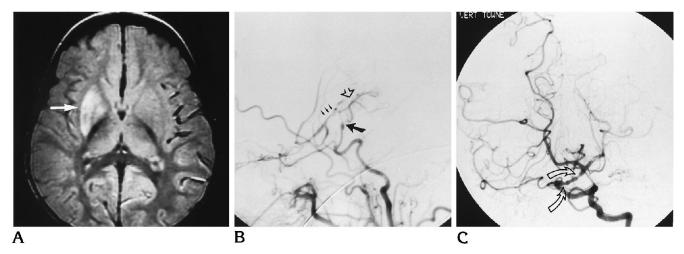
A, Axial magnetic resonance image (2000/80/1) of the brain shows increased signal within the right putamen and globus pallidus compatible with infarction (*arrow*).
